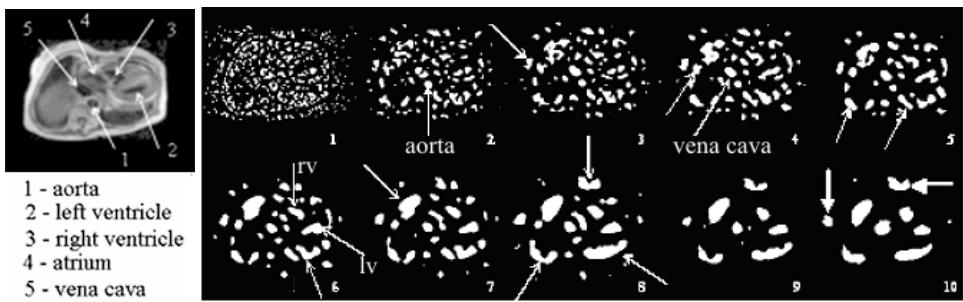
(left): slice of a T1 spin echo MRI thoracic sequence, the arrows point to the five target structures. (right) Dark blobs from 9 levels of the scale space of the image shown in (a). Values of σ are: $\sigma_1 = 1.0$ (original image), $\sigma_2 = 1.19$; $\sigma_3 = 1.41$; $\sigma_4 = 1.68$; $\sigma_5 = 2.00$; $\sigma_6 = 2.37$; $\sigma_7 = 2.82$; $\sigma_8 = 3.35$; $\sigma_9 = 3.97$; $\sigma_{10} = 5.61$. (Original image acquired at the Imaging Department - Heart Institute - HCFMUSP- with patient anonymization).
